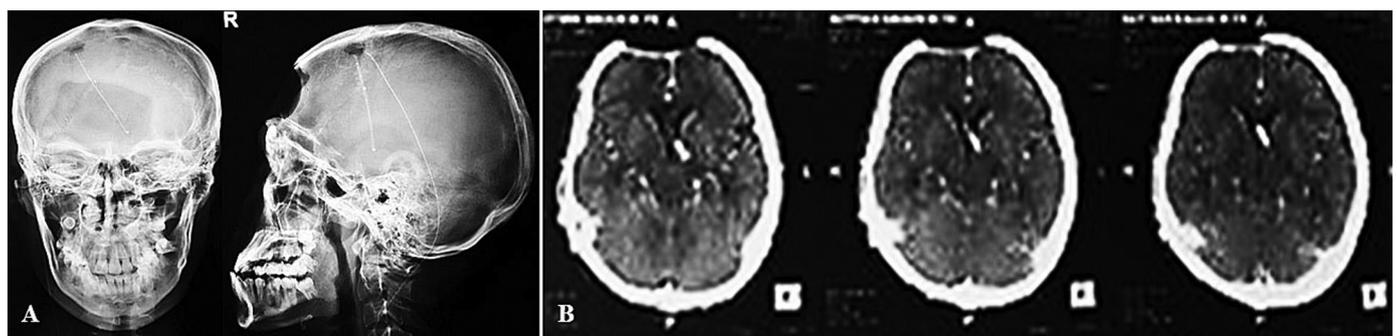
Follow-up Skull X-ray (A) and contrast CT image (B) after VP shunting and 6-week administration of antibiotics. As seen on the images, there was no sign of hydrocephalus and no enhancement mass were identified. We also noted that the meningeal enhancement could not be acknowledged any longer when compared with the previous CT images.
